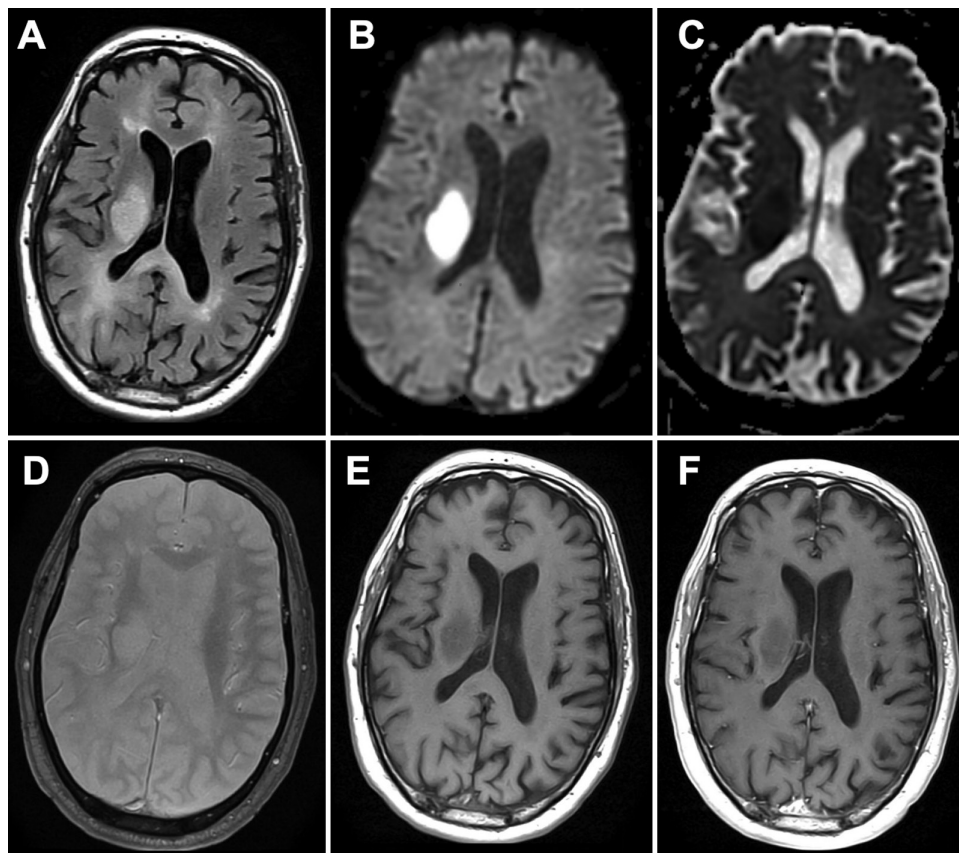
Initial MR images of the brain demonstrating right basal ganglia ischemic stroke-like changes. T2-FLAIR (A), diffusion-weighted (B), ADC (C), and susceptibility-weighted (D) sequences demonstrating a well-defined, hyperintense, diffusion-restricting lesion in the right basal ganglia. The lesion does not demonstrate contrast enhancement, as seen by T1-weighted pre- (E) and post-contrast (F) sequences, being most consistent with subacute ischemic stroke.
